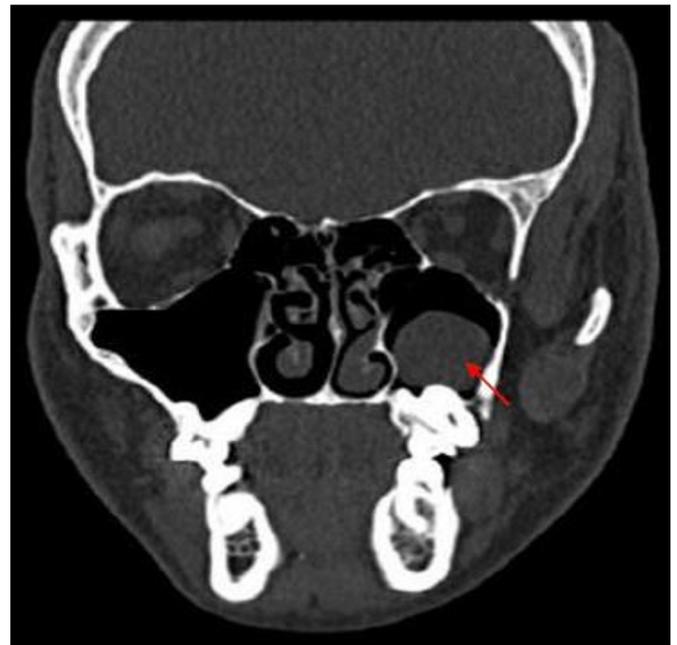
Preoperative coronal CT image showing unilateral sinusitis which was clinically silent on left side (arrow).
